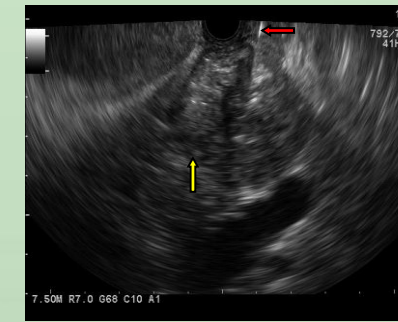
Fine needle aspiration (red arrow) of the pancreatic mass (yellow arrow) under endoscopic ultrasound guidance.
